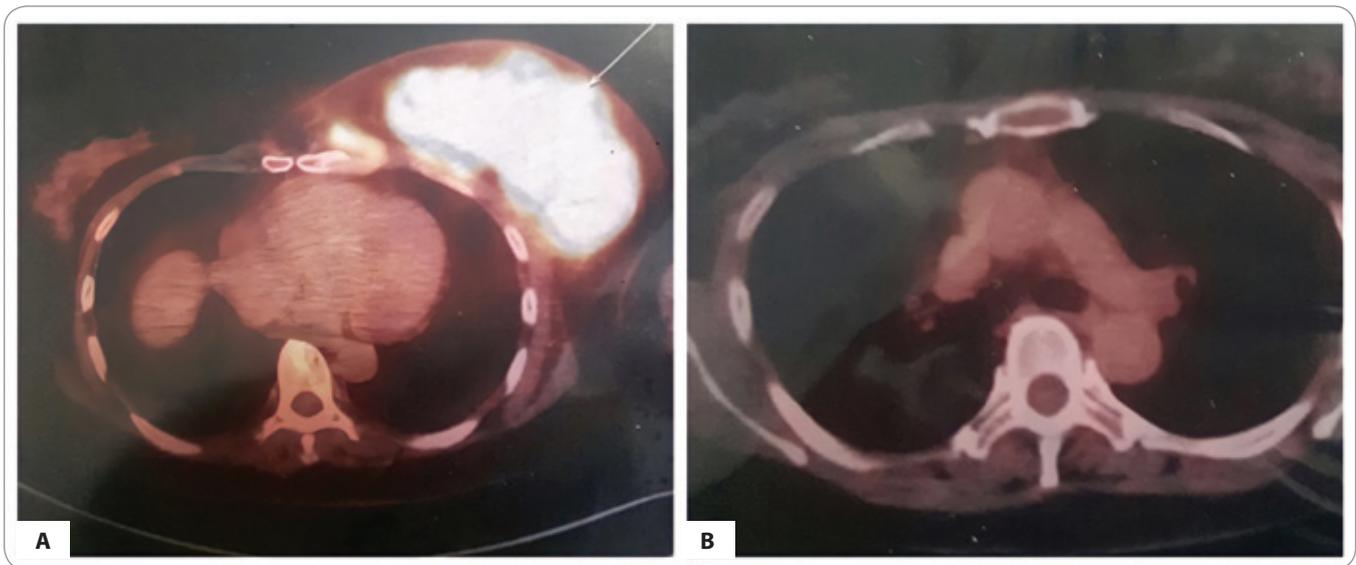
PET/CT Scan. A) before therapy; B) after therapy.
